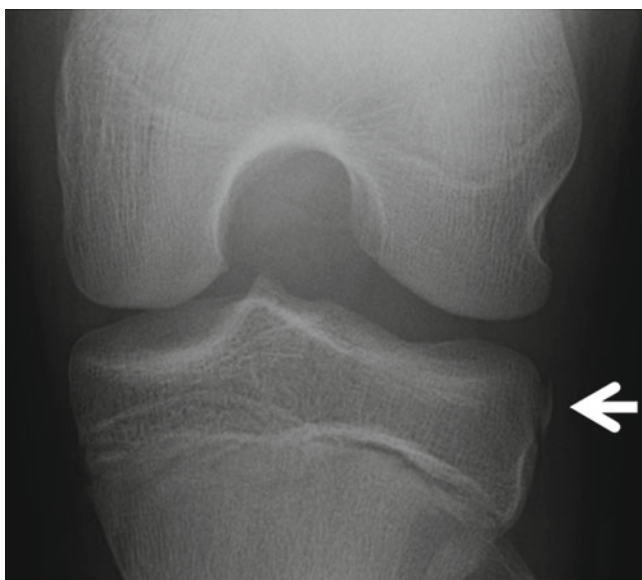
X-ray appearance of a Segond fracture. In 1879, Paul Segond recognized that patients who had a small avulsion fracture off the anterolateral tibial plateau (*arrow*) typically had an ACL tear
